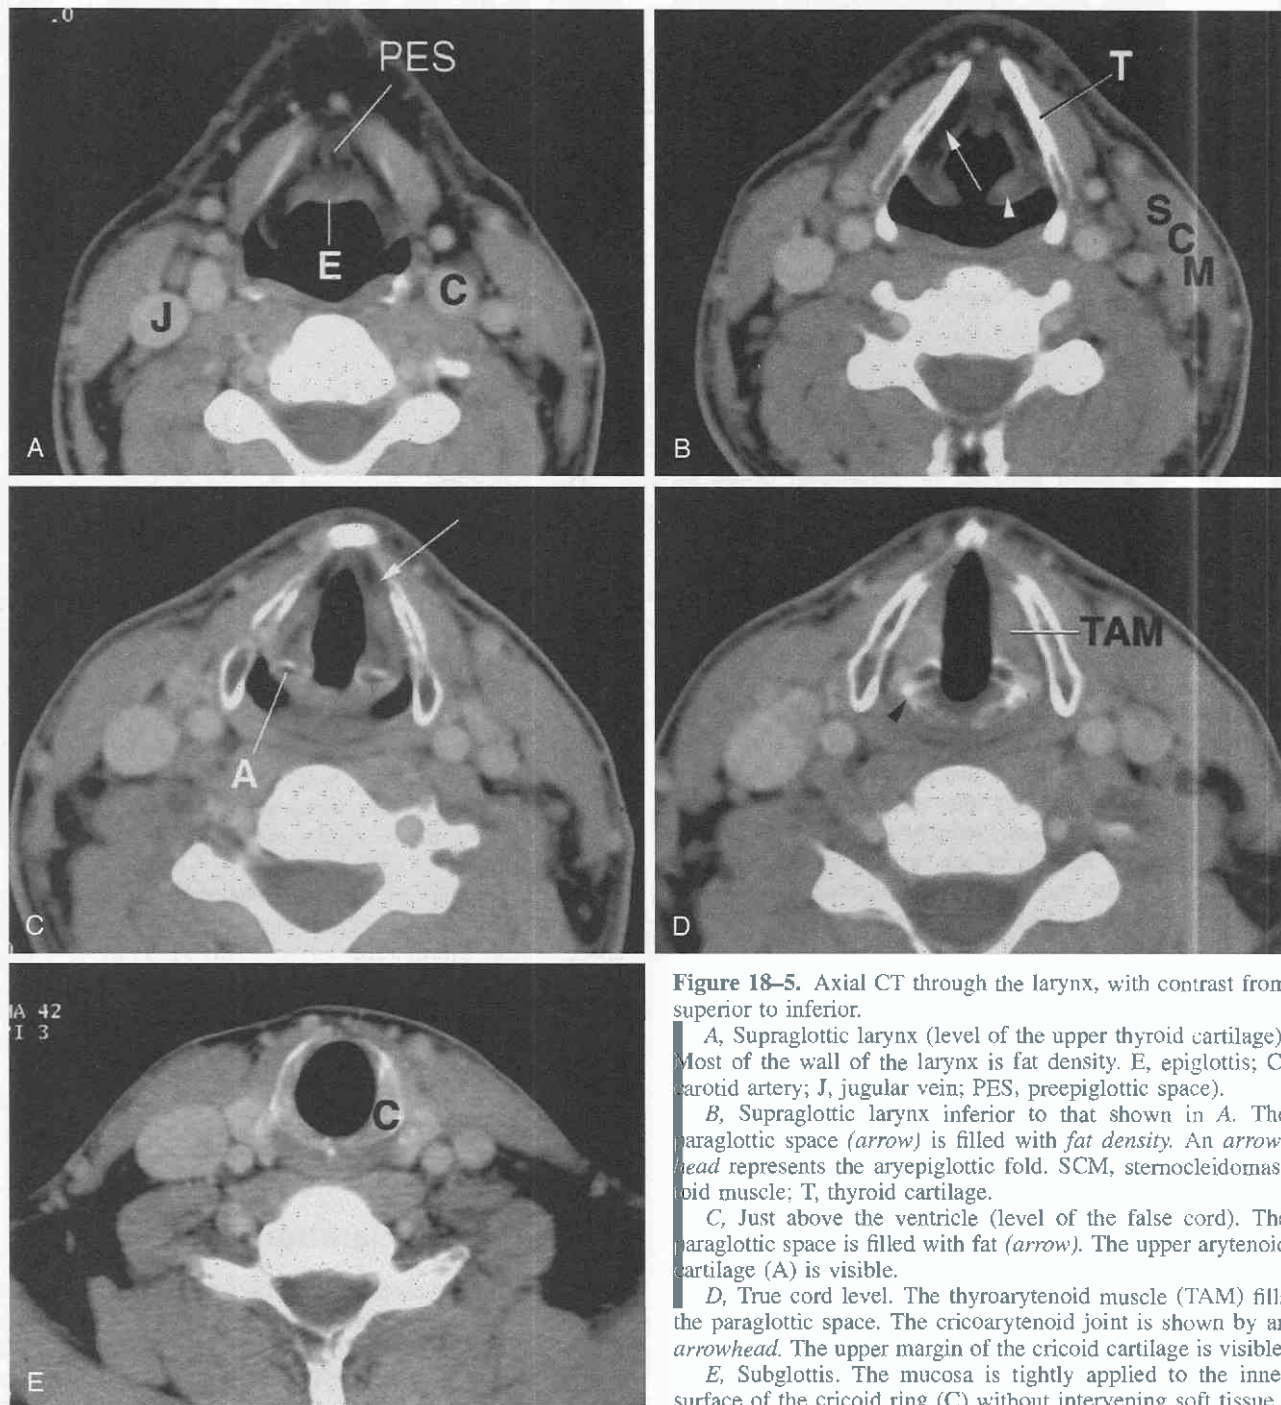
Axial CT through the larynx, with contrast from superior to inferior.
